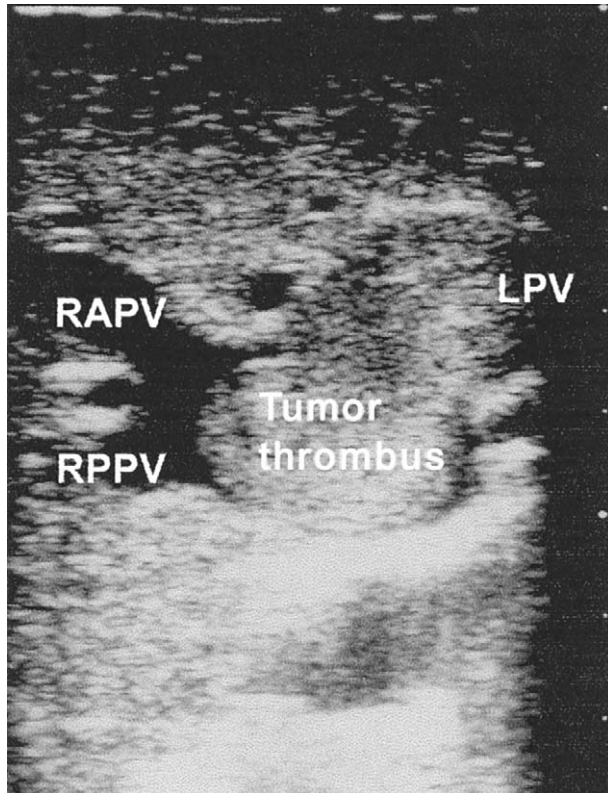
Intraoperative ultrasound showing tumor thrombus of the left portal vein, almost completely obstructing the bifurcation. LPV = left portal vein; RAPV = right anterior portal vein; RPPV = right posterior portal vein.
